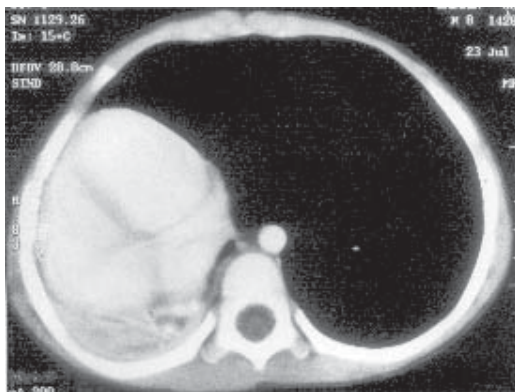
CT scan of chest showing herniation of hyperinflated left lung and atelectatic right lung in right paravertebral gutter.
